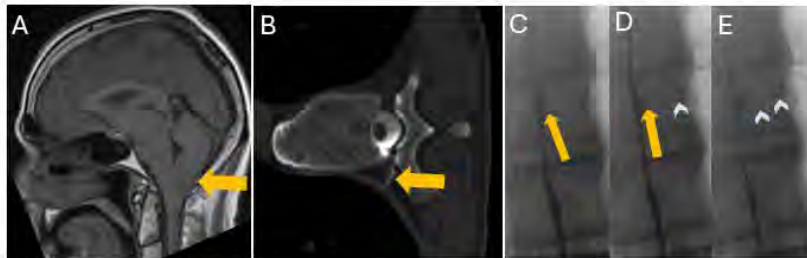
A 50-year-old patient presented with headache. (A) Sagittal brain MRI demonstrates brainstem sagging and inferiorly displaced cerebellar tonsils (arrow). (B) Right lateral decubitus photon counting CT myelography demonstrates curvilinear contrast arising from the thecal sac into right paraspinal soft tissues (arrow). (C-E) Lateral decubitus DSM images demonstrate progressive filling of a contrast outpouching extending from the thecal sac into the right paraspinal soft tissues with subsequent opacifying of right paravertebral veins (arrowheads), consistent with a CSF-venous fistula.
